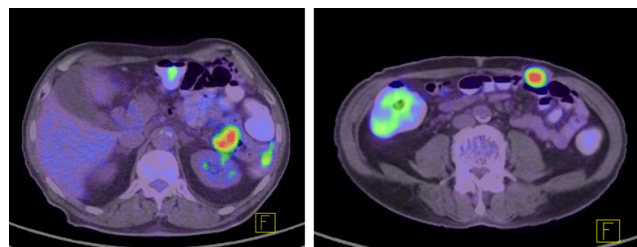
PET-CT: recidive abdominale cu localizare intraabdominală și parietală.
